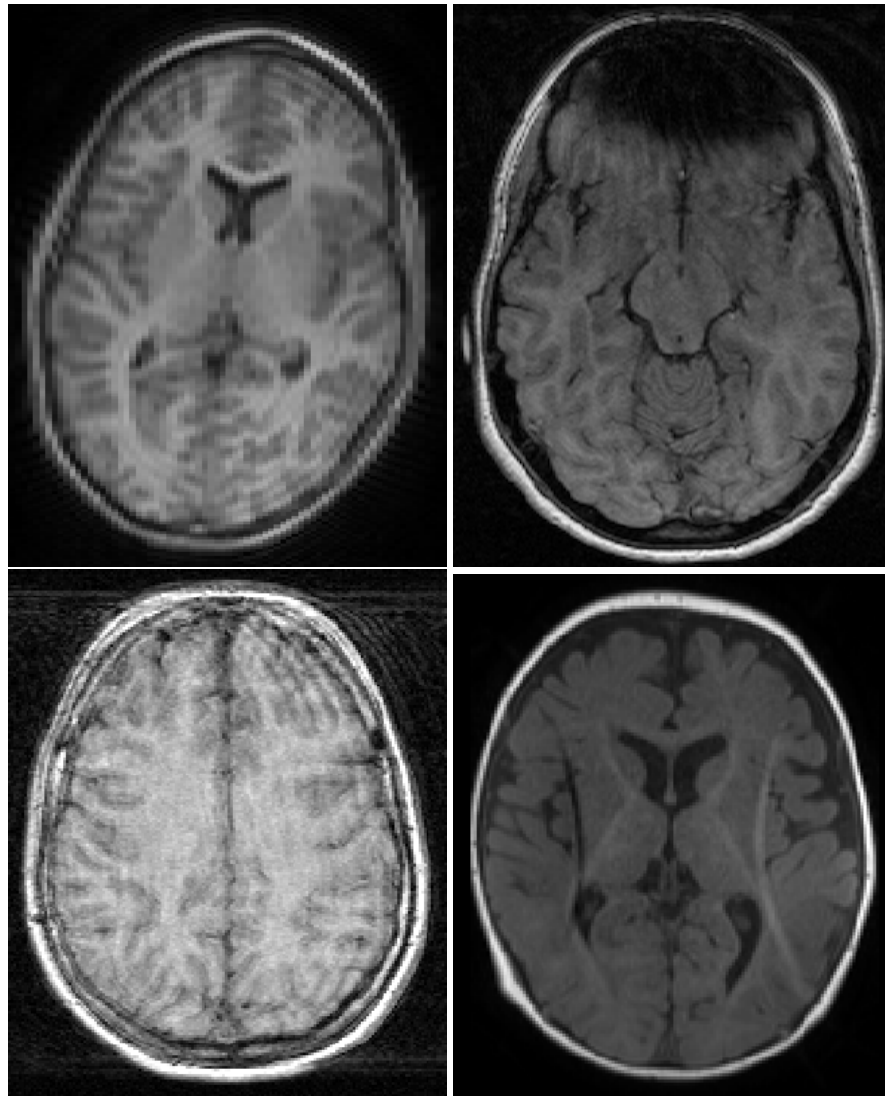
Participants excluded due to MRI artefact. Axial MRI example scans of participants who were excluded due to imaging artefacts degrading the data and preventing accurate automated analysis
